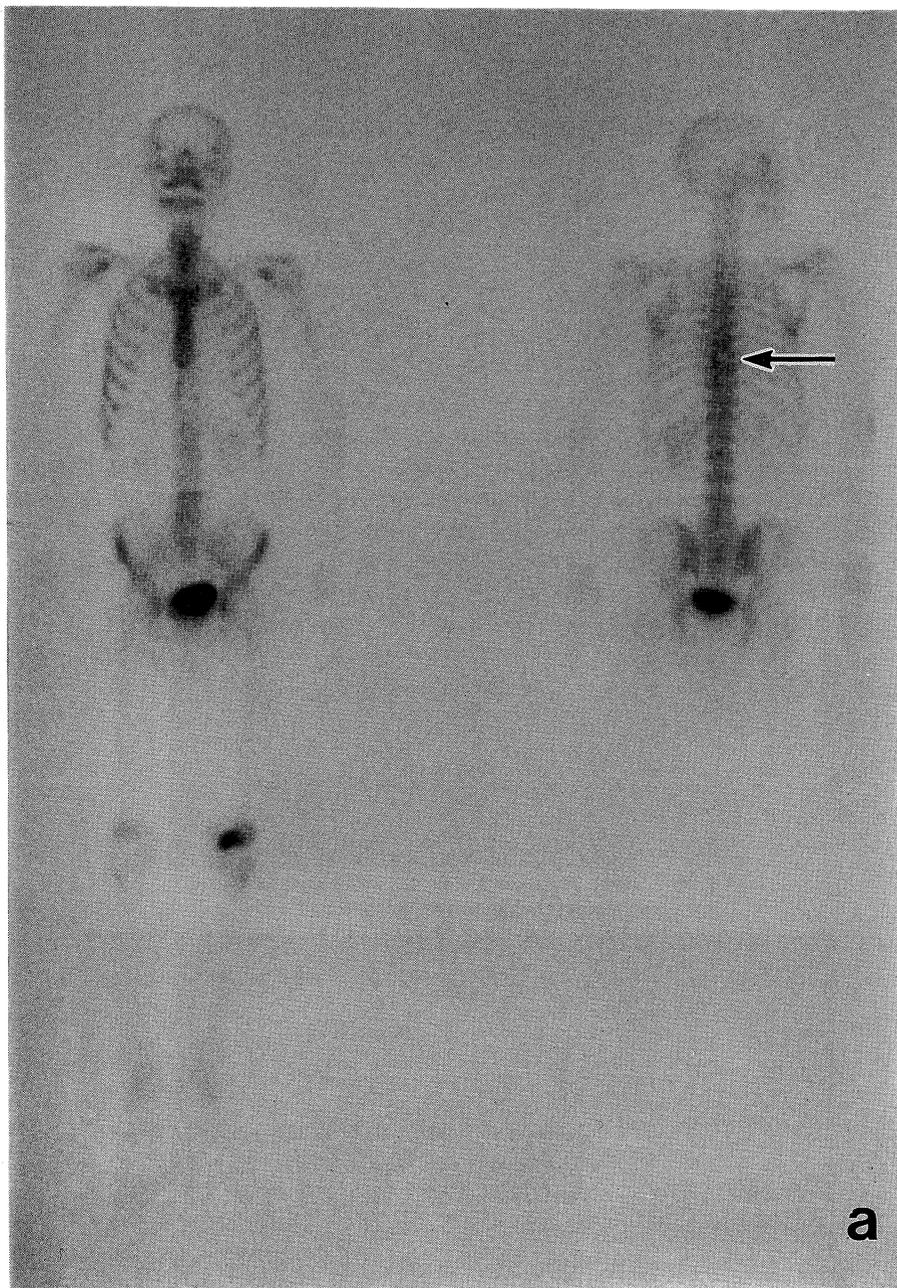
Bone scintigraphy showed cold defect, nearly normal pattern, in the eighth thoracic vertebra.
